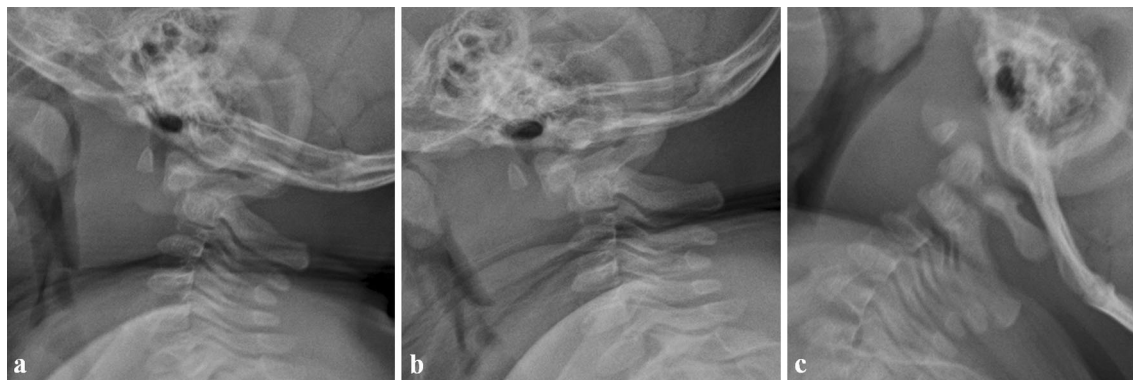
a A lateral view of the cervical radiograph shows atlantoaxial subluxation and prevertebral soft tissue swelling. The displacement between the odontoid process and the body of axis widened on flexion view (b) and reduced on extension view (c)
